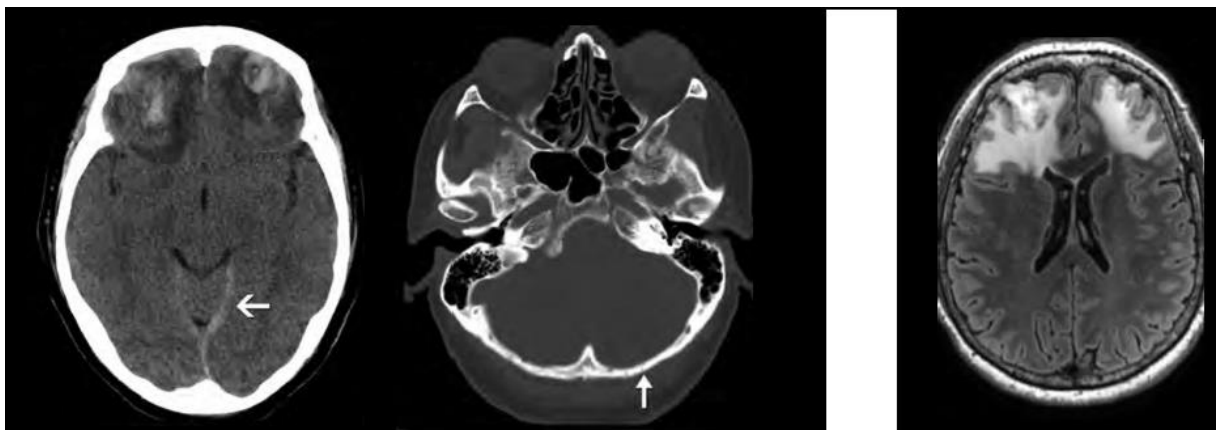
(Left) CT images show a nondisplaced left occipital fracture (arrow) with an underlying hemorrhagic contusion in the left cerebellar hemisphere. (Right) These lesions have
